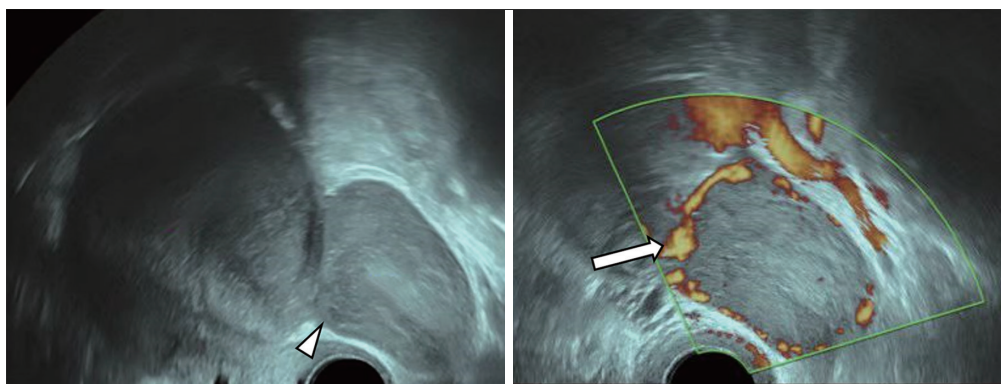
Pelvic ultrasonography detected a well-defined hypoechoic mass (white arrowhead) with blood flow signals (white arrow) visible in the left adnexal area.
